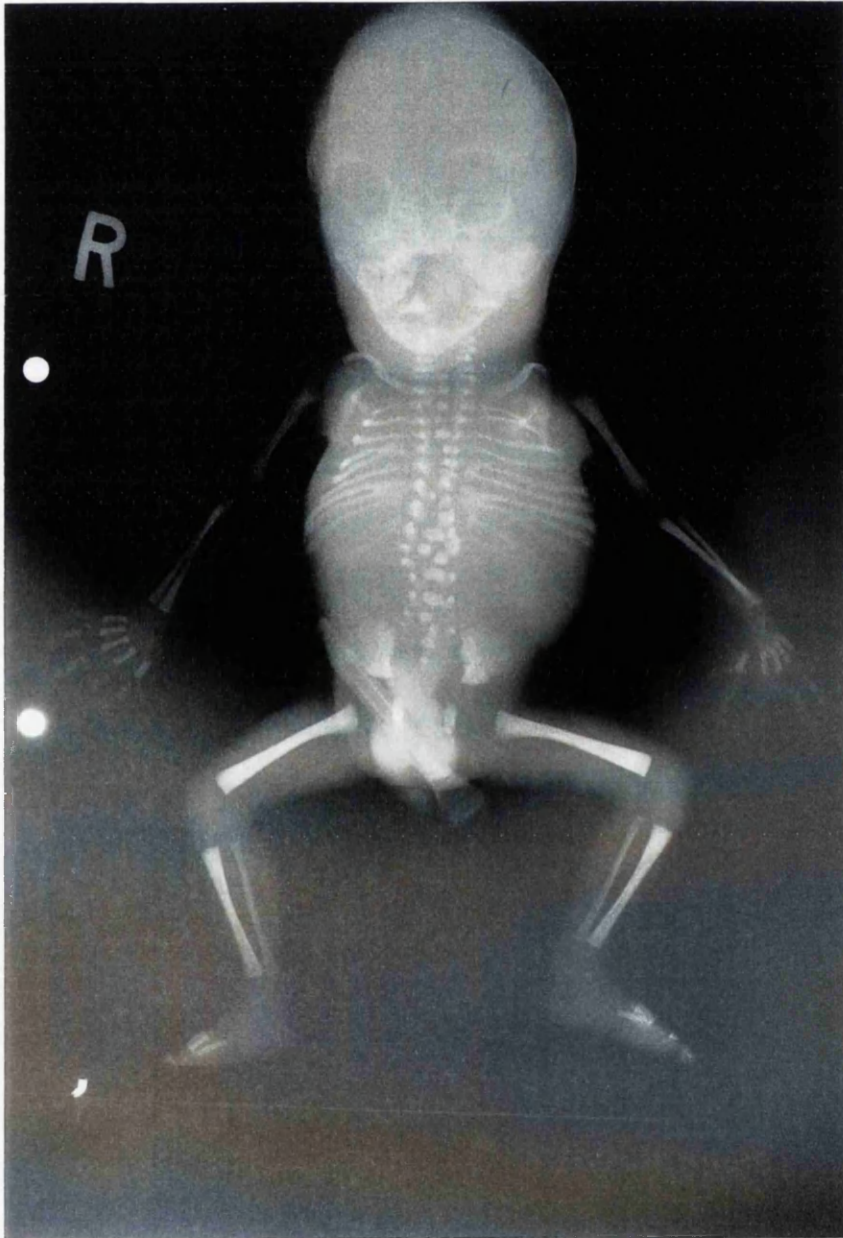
Radiography of case No 45 showing vertebral anomalies with many hemivertebrae in the thoracolumbar region and ribs anomalies characteristic of having Jarcho-Levin syndrome.
